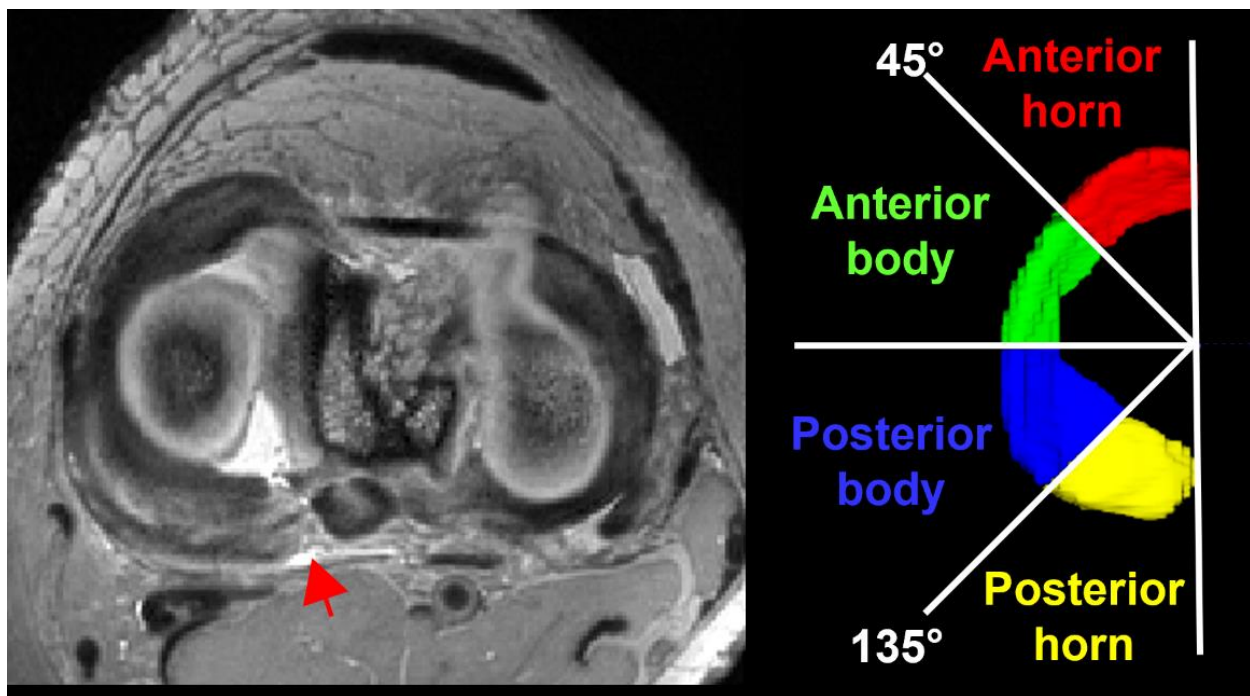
Left: Axial T2-weighted image showing medial meniscus posterior horn root tear (MMPRT) (arrow). Right: Regiondefinition.
